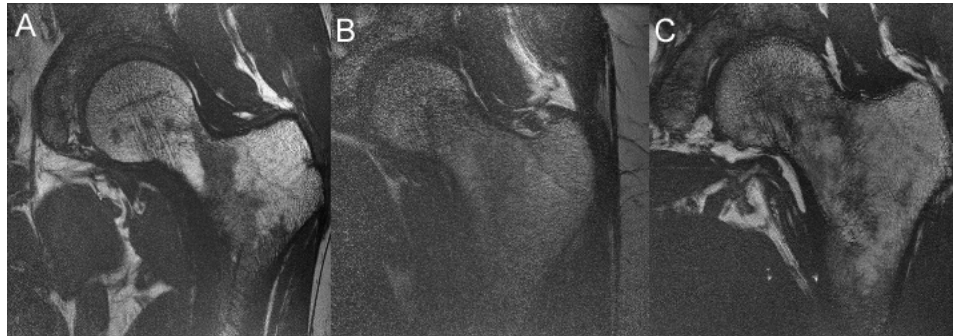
Example of a MR image of the proximal femur with (A) good image quality, (B) low SNR, and (C) motion. Poor image quality and motion artifacts similar to B and C are typical exclusion criteria in clinical studies and cause registration to fail.
